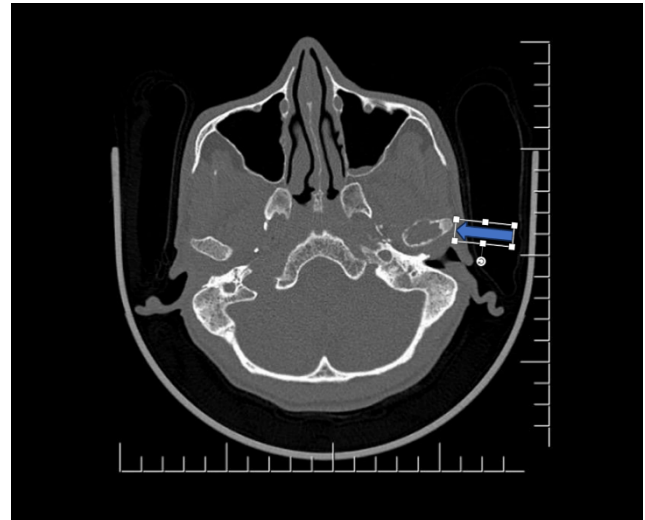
Axial CT image (bone window) depicting a small lytic focus in the left mandibular condyle (arrow), without significant cortical expansion.
